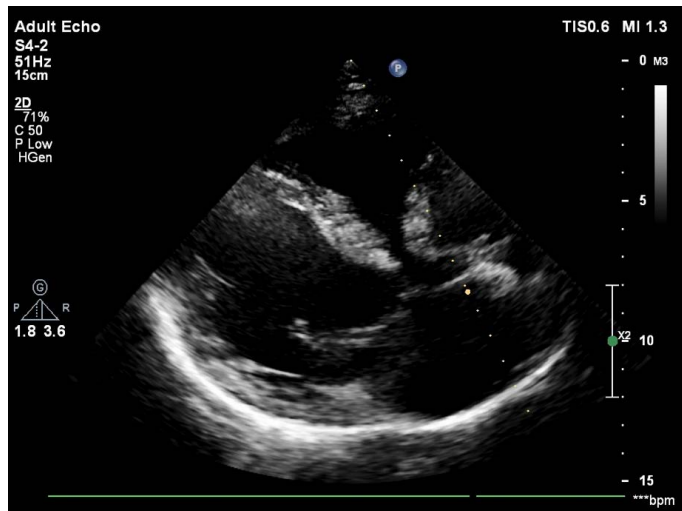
Transthoracic echocardiography performed four months after initiation of treatment shows no evidence of thrombus formation within the right atrial appendage aneurysm.
